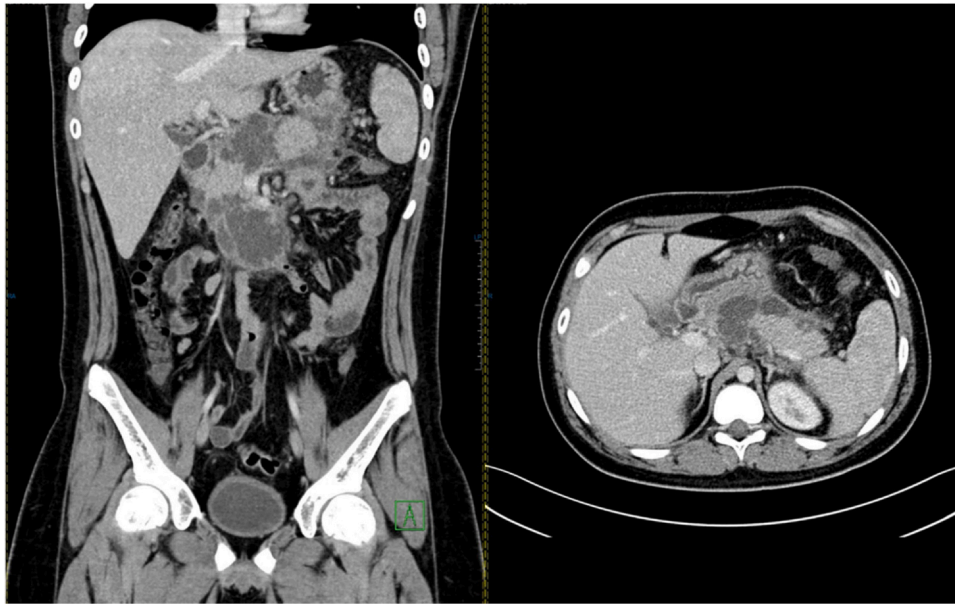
Contrast-enhanced abdominal computed tomography (CT) with evidence of thrombosis involving branches of the anterior and posterior segments of the right portal vein.
